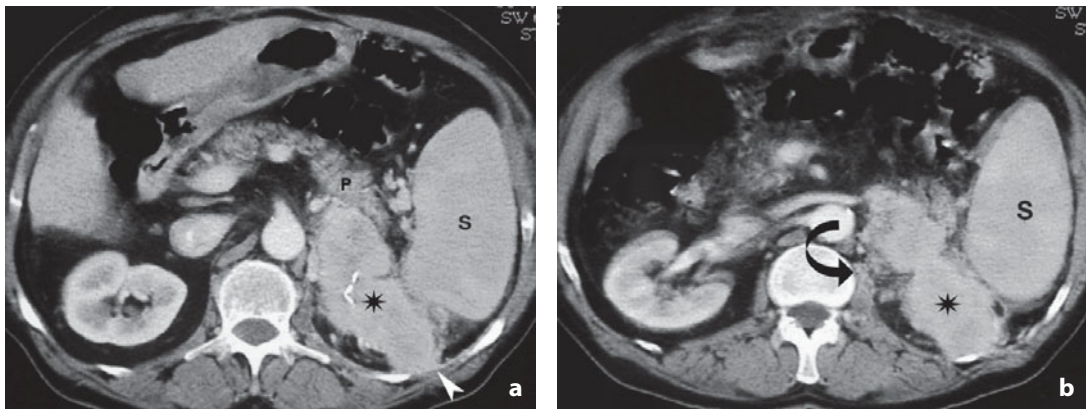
Computed tomography. Local-regional recurrence following left radical nephrectomy. The images show a large mass (asterisk) growing in the empty renal space, invading the transverse fascia (arrowhead) and in contact with the spleen (S), the tail of the pancreas (P) and the ileo-psoas muscle (curved arrow)
